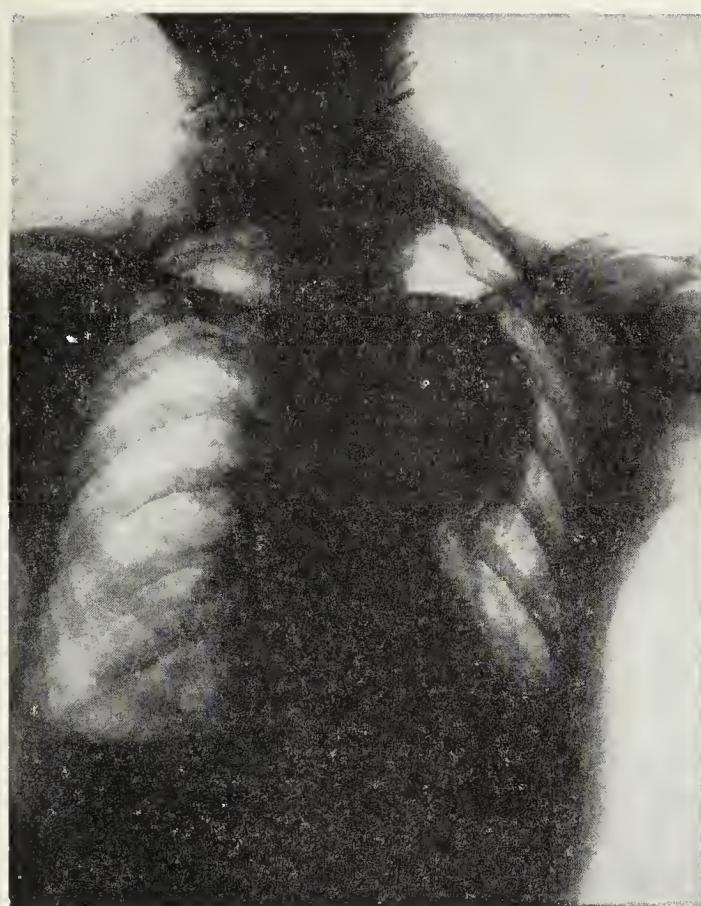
X-ray films of the chest as an aid in the differential diagnosis of chest pain. (H. H. Hecht.)
